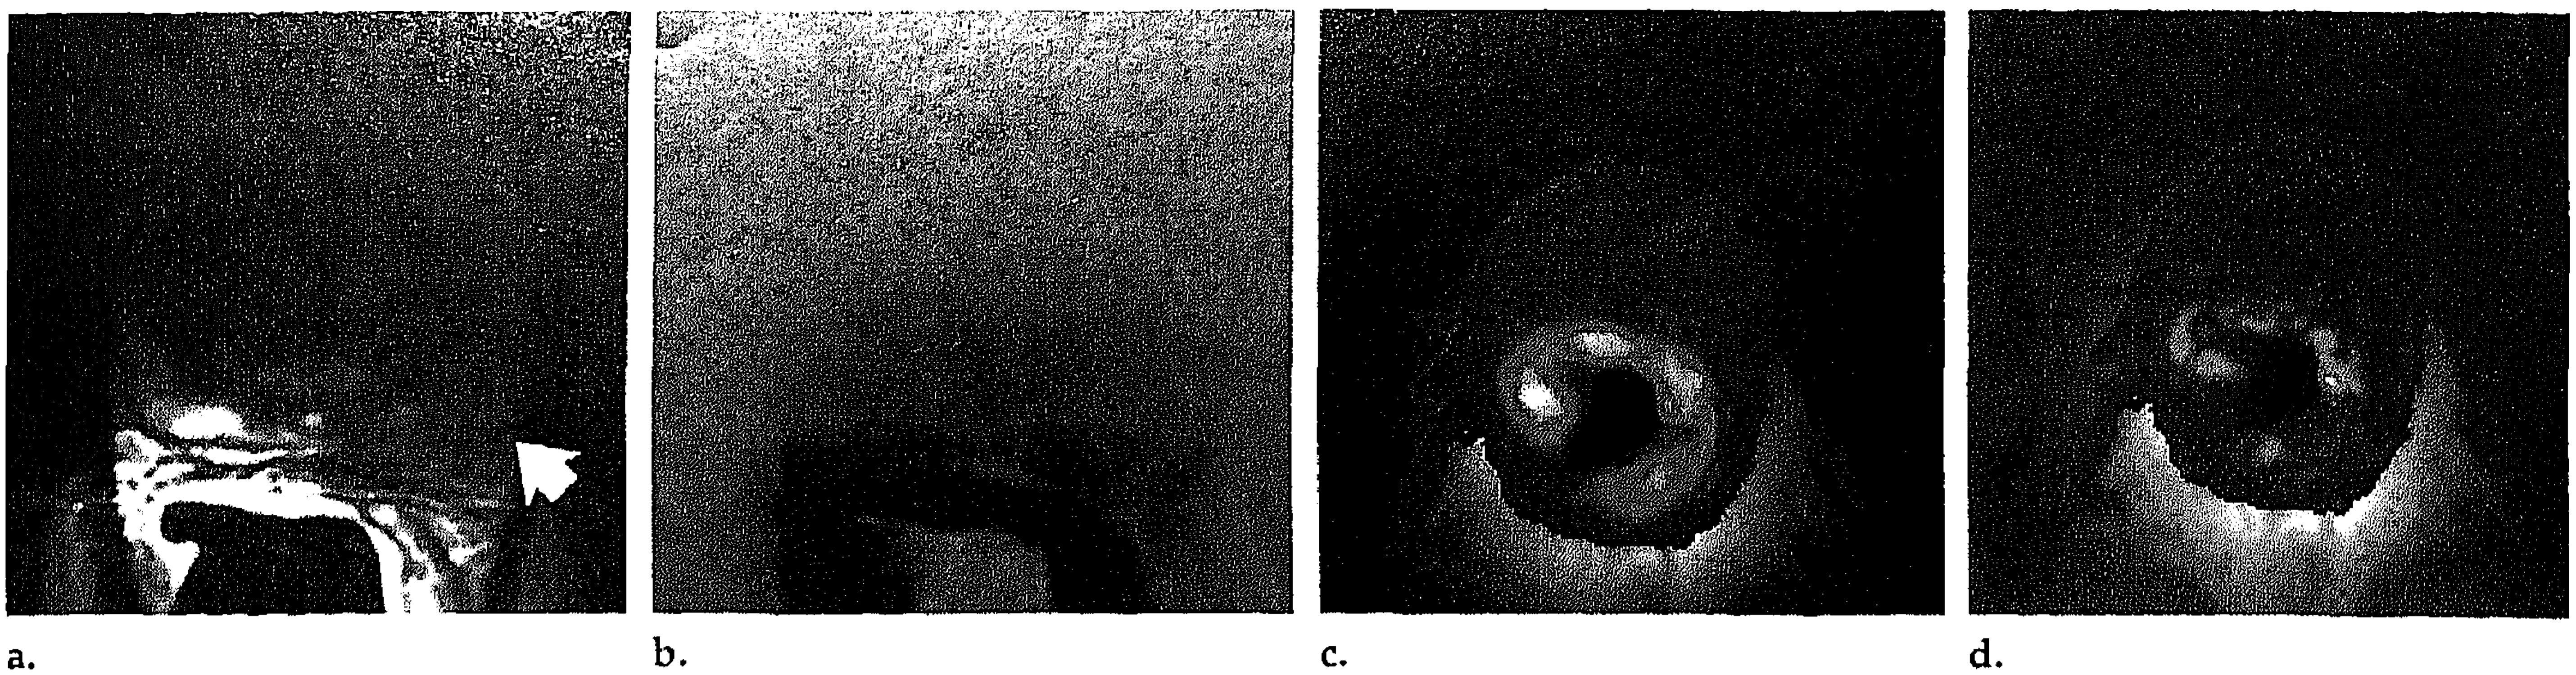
Case of a 66-year-old man with prostate cancer. (a) T2-weighted fast SE image shows a low-signal-intensity area on the left side and bulging of the contour (arrow). This was interpreted as a T2 tumor by one observer and a T3 tumor by the other. (b) Dynamic subtracted TurboFLASH image shows little enhancement. (c) Time image shows late enhancement, and (d) slope image shows slow enhancement. No tumor was found at the corresponding level at final pathologic examination.
